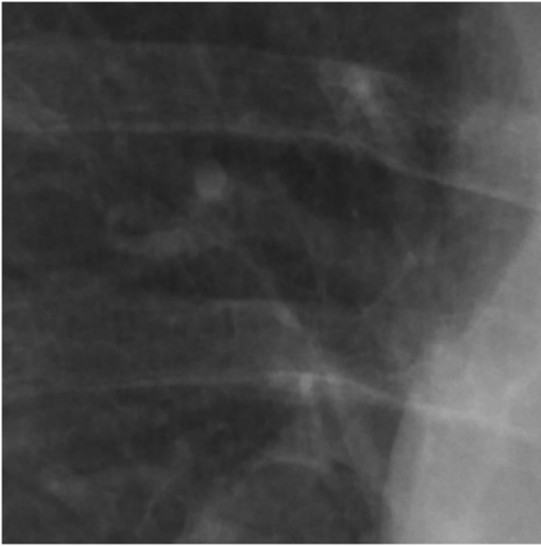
A detail in the lung of a patient chest X-ray image.
